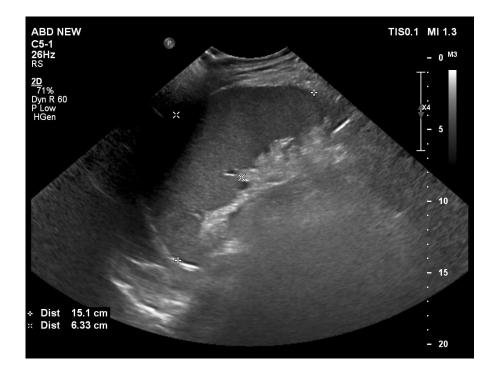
2D grey scale ultrasound image shows an enlarged spleen measuring - 15.1 cm on the long axis - suggestive of splenomegaly.
